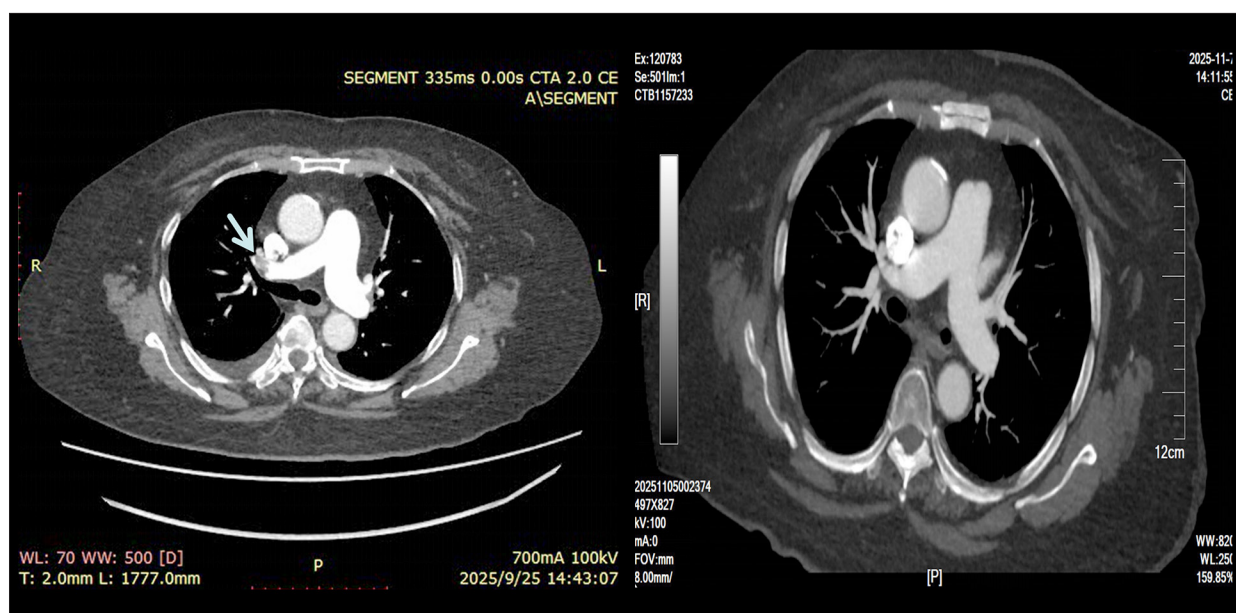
Pulmonary computed tomography angiography imaging. The image on the left is pulmonary embolism; the arrow indicates the thrombus. The image on the right confirms the disappearance of thrombus after anticoagulant therapy.
